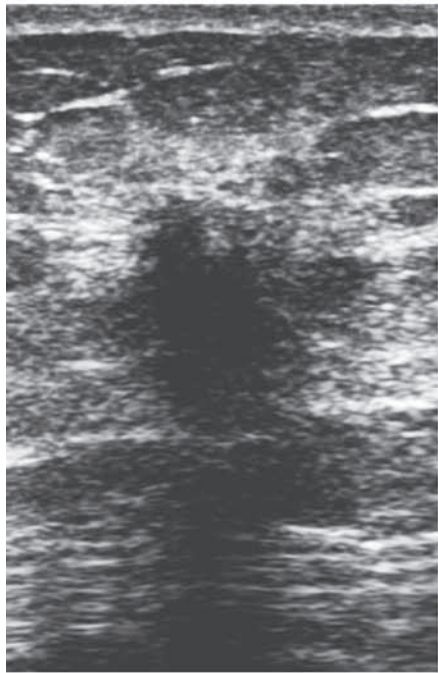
Nipple retraction and underlying architectural distortion in an 80-year-old woman who presented with left nipple retraction and breast hardness. (a, b) Craniocaudal (a) and mediolateral (b) mammograms show prominent nipple retraction with an area of architectural distortion at the twelve o'clock position in the anterior left breast. The distortion was not seen at mammography performed 16 months earlier. The radiopaque circular marker denotes a skin mole. (c) US image shows a large, irregular, spiculated mass with posterior shadowing. (d) Sagittal postcontrast maximum-intensity-projection MR image shows a spiculated, heterogeneously enhancing mass with several smaller adjacent ill-defined enhancing masses (arrowheads) extending to the nipple. Note the retraction of the skin and nipple with asymmetric enhancement of the nipple (arrow). Pathologic analysis revealed a large ILC extending to the nipple, with tumor involvement in the deep dermis.
